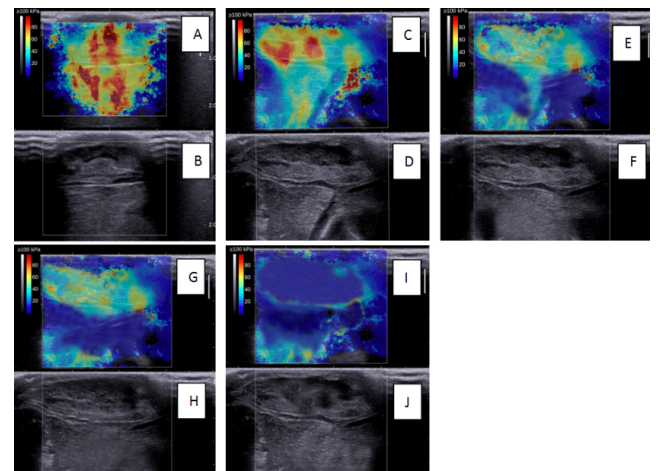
SWE ultrasound images at different time points after HIFU ablation. (A, B): 1 day after HIFU ablation, ablation zone of SWE ultrasound image was mainly red-yellow with colourful mosaic; (C, D): 3 d after HIFU ablation, the red area in ablation zone of SWE ultrasound images reduced; (E, F): 7 d after HIFU ablation, ablation zone of SWE ultrasound image was mainly blue-yellow; (G, H): 14 d after HIFU ablation, ablation zone of SWE ultrasound image was similar to those of 7 d after HIFU ablation; (I, J): 30 d after HIFU ablation, ablation zone of SWE ultrasound image was mainly blue, and partial liquefaction necrosis area could be seen in two dimensional ultrasonography.
